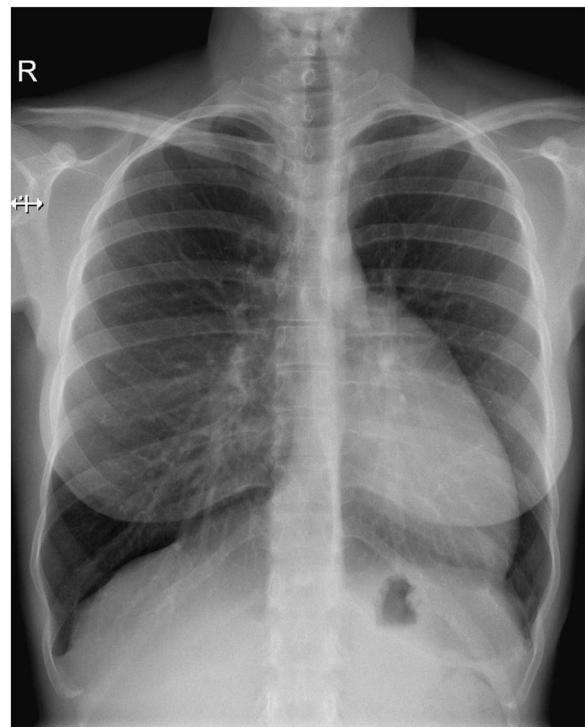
Chest radiography showing leftward displacement of the heart (with no projection of the cardiac silhouette on the right side of the spine) and a band of lucency between the heart and the diaphragm.
